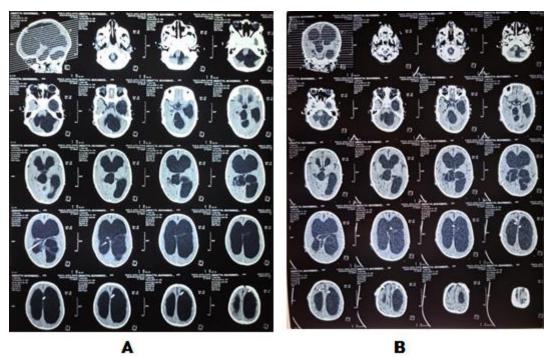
Case 1 of CT scan representation. (A) preoperative CT scan, (B) postoperative CT scan
